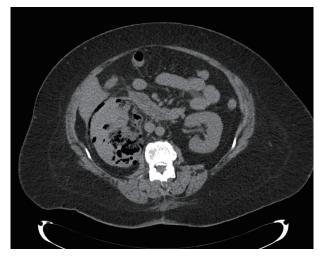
CT reveals crescent-shaped gas accumulation in the right perinephric area.
